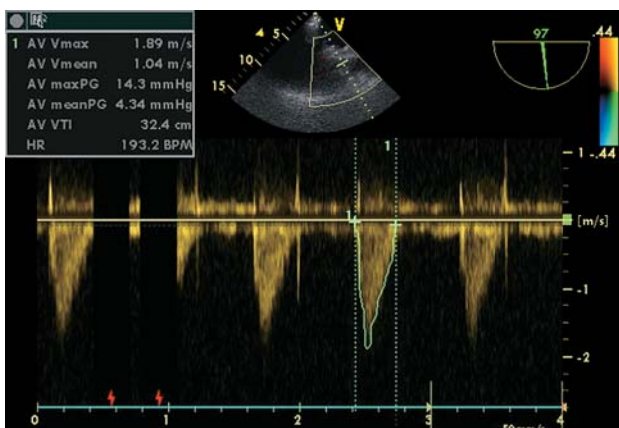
Transesophageal echocardiography (intraoperatively) in the same patient. Continuous wave Doppler study. AV systolic pressure gradient measurement. Peak systolic gradient on the aortic valve after prosthesis implantation is 14 mmHg, mean – 4.3 mmHg.
